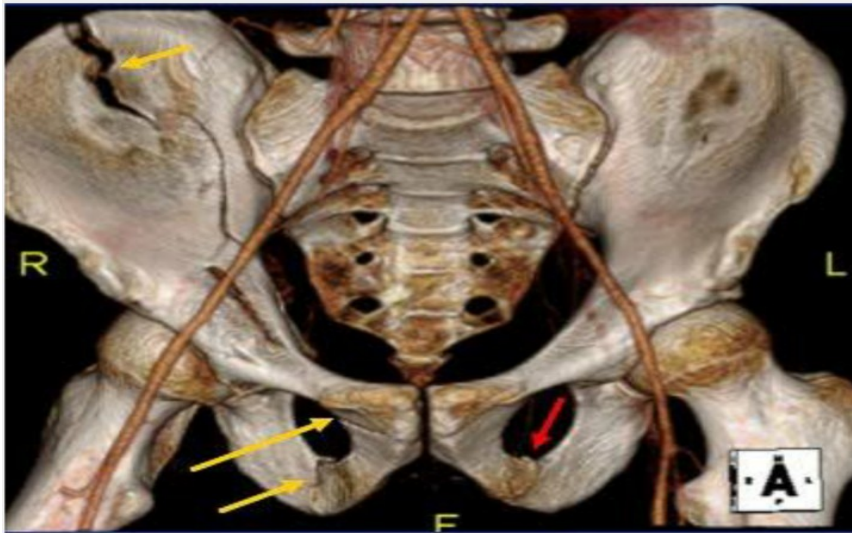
CT pelvis show multiple fractures of pelvis
